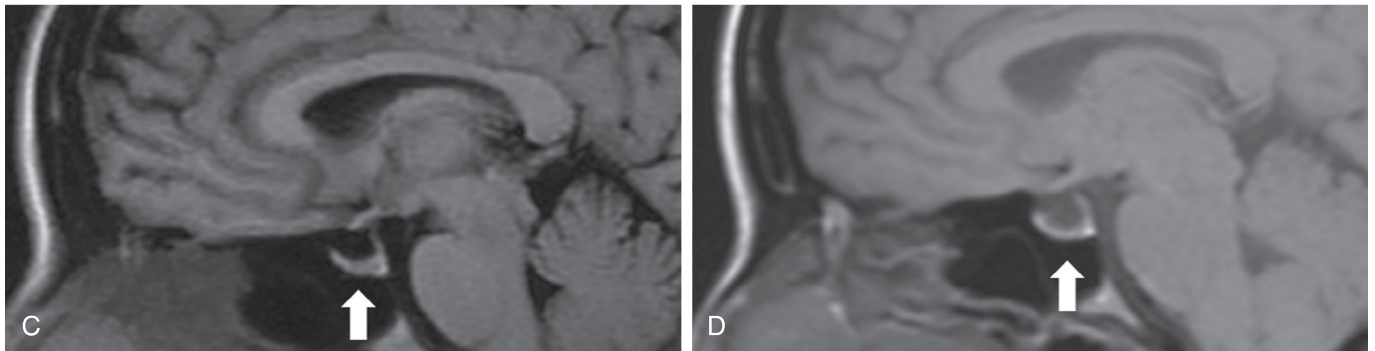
cont'd There is a mild partially empty sella with mild flattening of the pituitary gland on initial sagittal T1-weighted imaging (C, arrow). Four years later, there is progression with more pronounced flattening of the pituitary gland (D, arrow).
